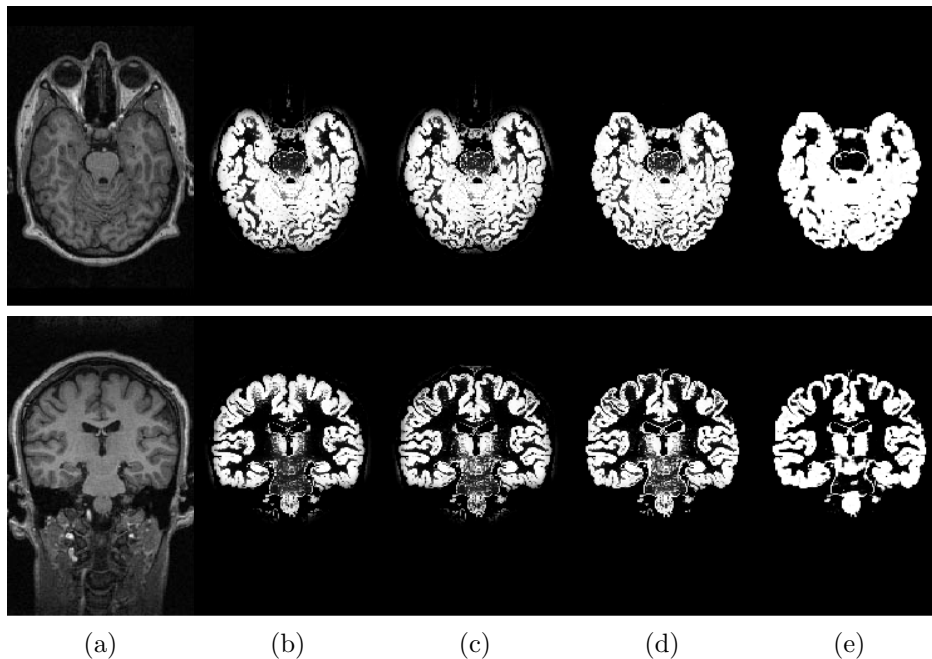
Example of how the different components of the algorithm work. From left to right: T1-weighted image (a), gray matter segmentation without bias field correction and MRF (b), gray matter segmentation with bias field correction but without MRF (c), gray matter segmentation with bias field correction and MRF (d), gray matter segmentation with bias field correction and MRF without constraints (e). (Source: Publication II)
